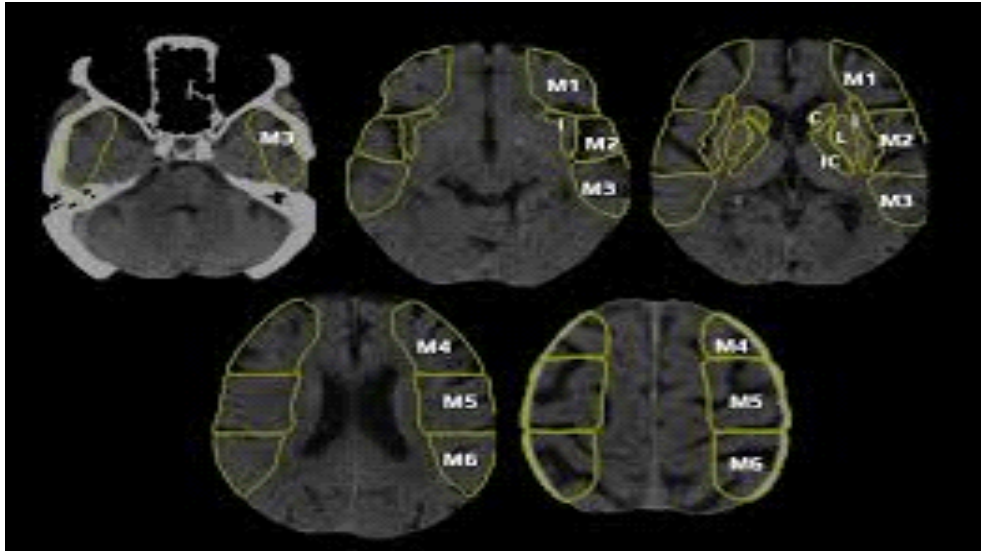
Basal Ganglia and supra ganglionic levels for ASPECT scoring.
